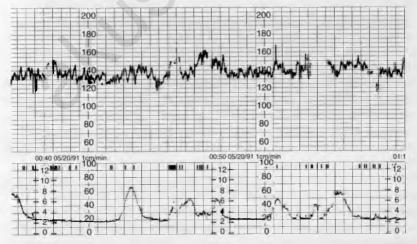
Hewlett-Packard 1350 with a combi transducer; automatic fetal movement recording is done through the ultrasound channel.
